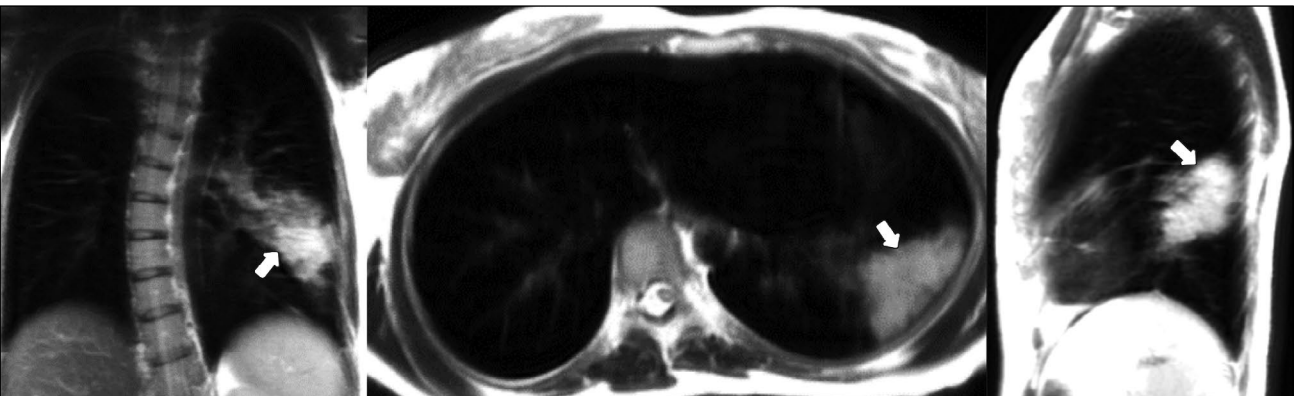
Dynamic magnetic resonance imaging of the lungs during exhalation in the coronal, axial, and sagittal planes. Arrows point to lesions with areas of both marked interstitial changes (the sign of the “cloudy sky”) and alveolar (compaction) changes that can be differentiated during inhalation (see Figure 3).
